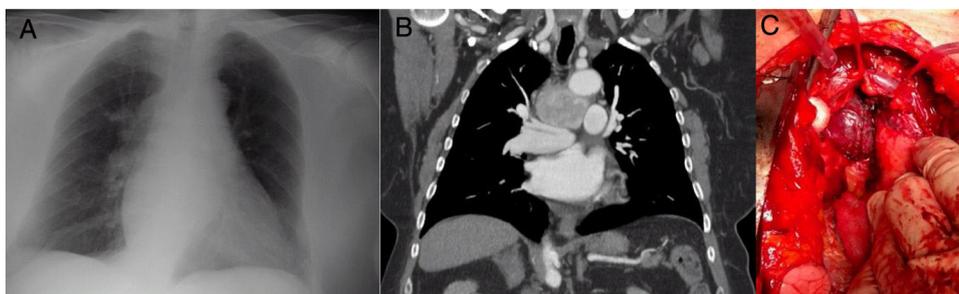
(a) Image of the mediastinal mass on chest X-ray. (b) Image of chest CT showing the mass in the middle mediastinum. (c) Paraganglioma during surgery, seen in the center of the image. The trachea is located at the top and the innominate vein is above it. The aorta is on the right and the pulmonary artery trunk below.
